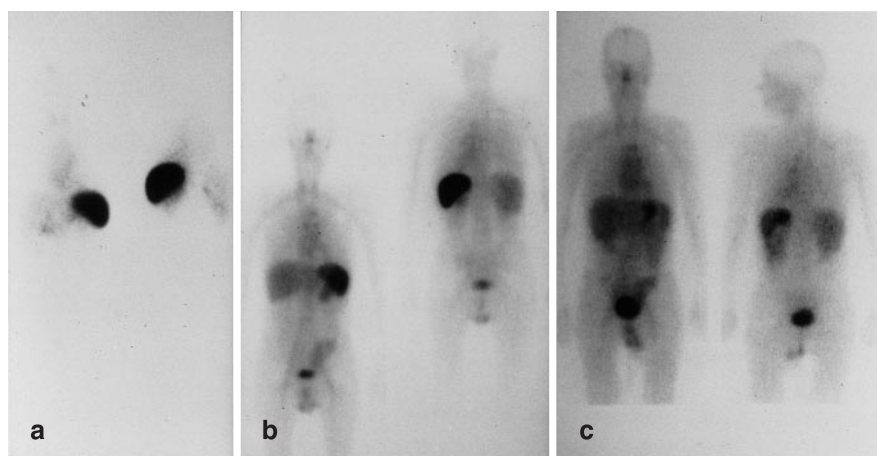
Serial anterior (*left*) and posterior (*right*) whole body ¹²³I-SAP scintigraphy in a patient with FAP (Table 2 patient 2), showing substantial regression of amyloid deposits in the spleen, kidneys and adrenal glands following OLT. The studies were performed 3 months before surgery (a), and 15 and 36 months afterwards (b and c, respectively)
